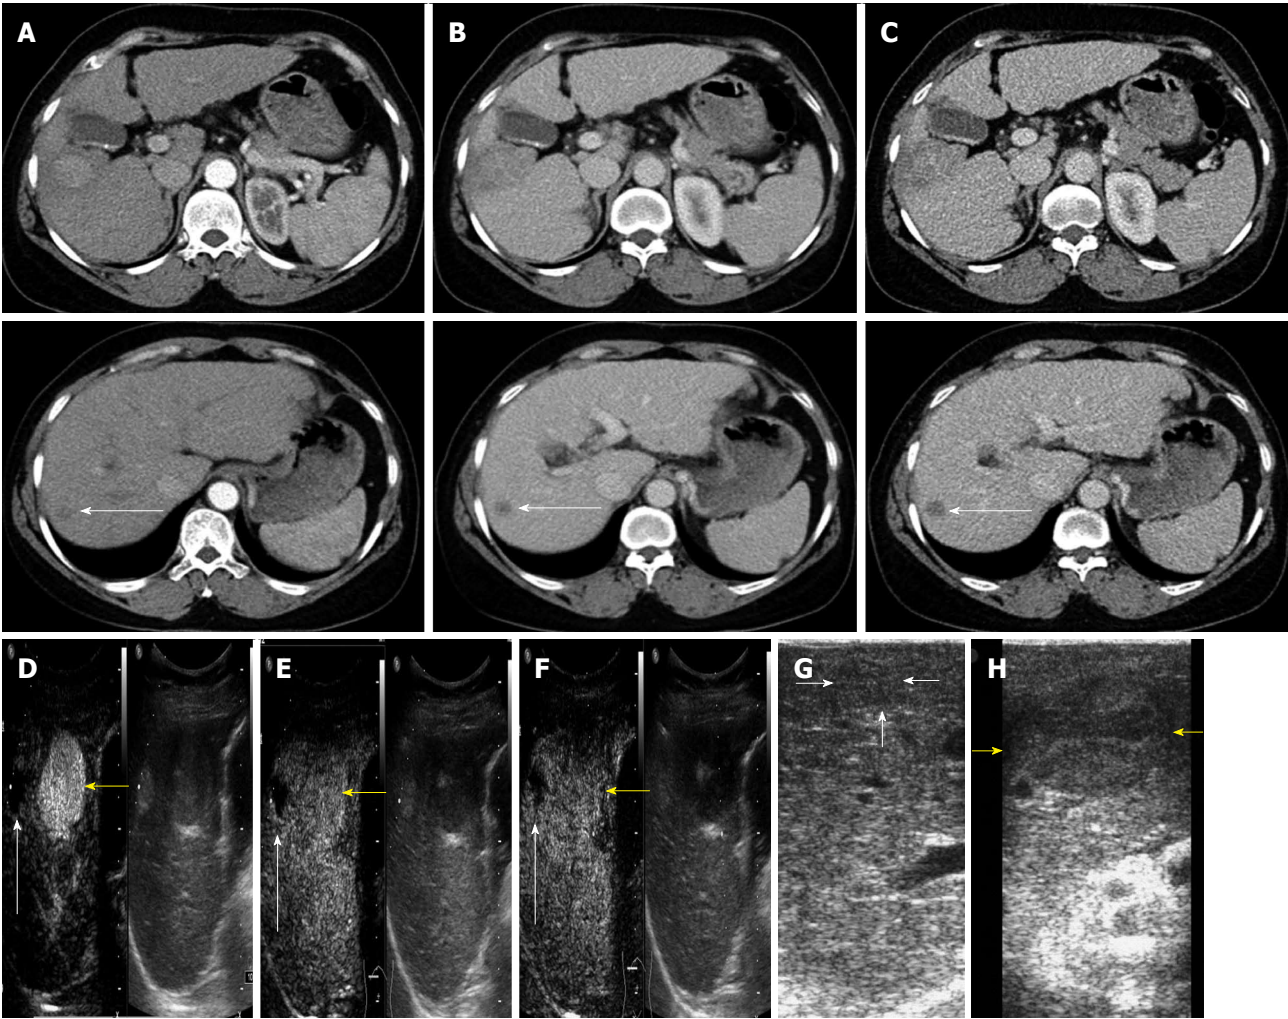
A 50-year-old man underwent right hepatic partial resection and left hepatic partial resection. A: CT just revealed the right HCC, not the left HCC which was identified by CEUS; B: Left HCC was discovered by conventional ultrasound; C-E: The left HCC was identified by CEUS in the arterial phase, portal phase and delayed phases; F: Right HCC identified by IOUS; G: Left HCC identified by IOUS. HCC: Hepatocellular carcinoma; CT: Computed tomography; CEUS: Contrast-enhanced ultrasound; IOUS: Intraoperative ultrasound.
